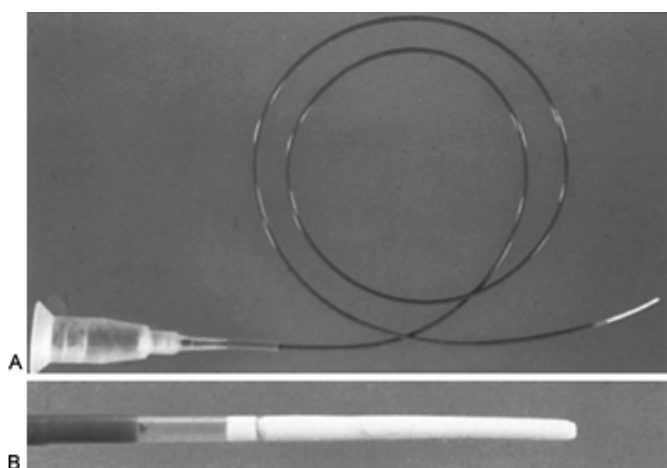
A: An endoluminal ultrasound catheter for intraluminal ultrasonography. The 7.2-Fr catheter passes over a 0.025-inch guidewire. B: The tip of the endoluminal ultrasound unit contains either a 12.5- or 20-MHz ultrasound unit capable of providing 360-degree scans of the ureter with a radius of 1.5 cm.
